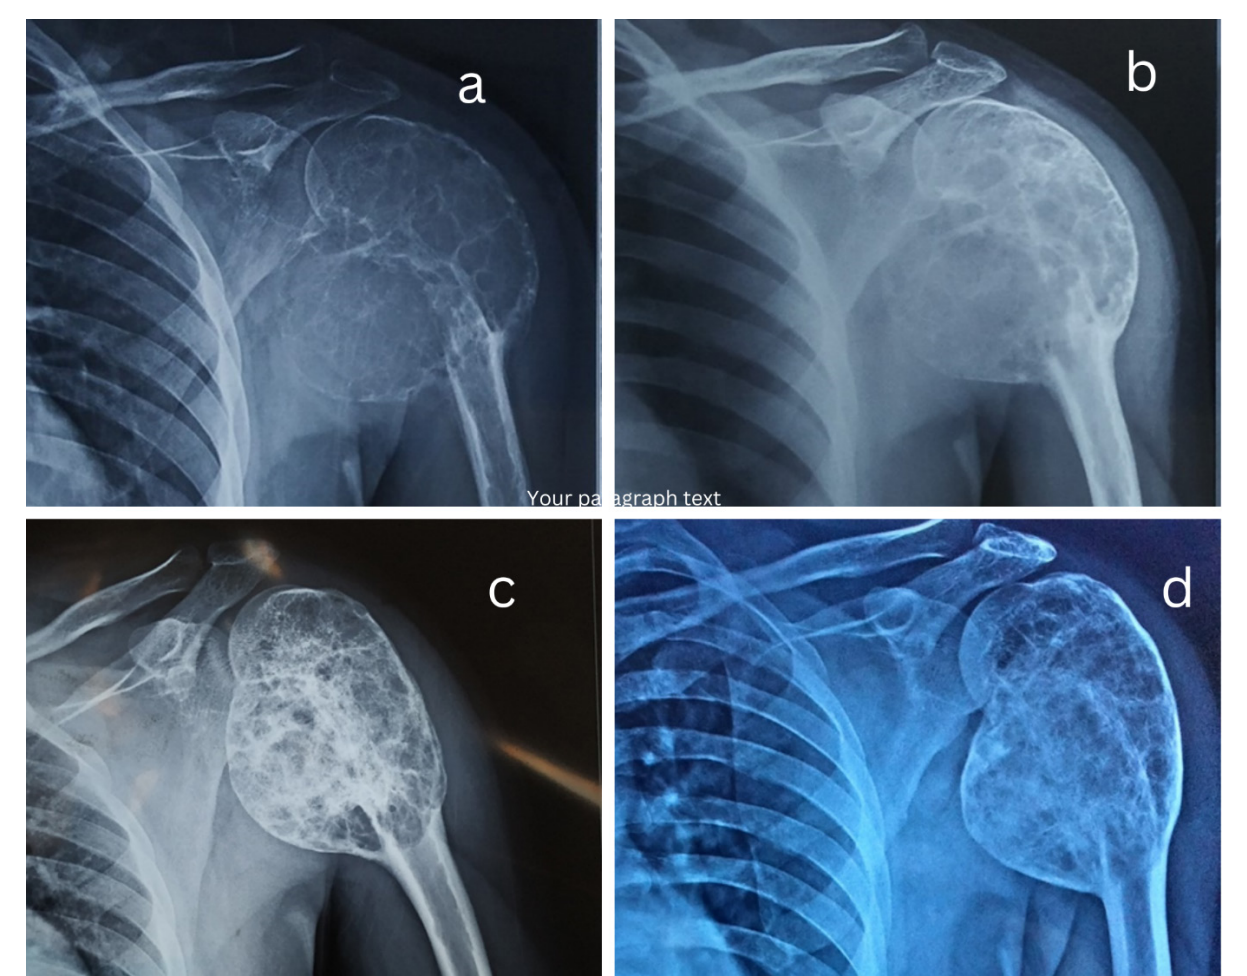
Radiographs showing an ABC affecting the proximal humerus of the left side in a 25-year-old male with meta-diaphyseal extension: (a) before treatment, (b) An AP radiograph taken after two injections of polidocanol shows an unopacified loculation in the medial part of the lesion, (c) radiograph was obtained at completion of treatment after three injections, (d) AP and lateral view radiographs showing the lesion at 40 months with remodelling of the lesion
